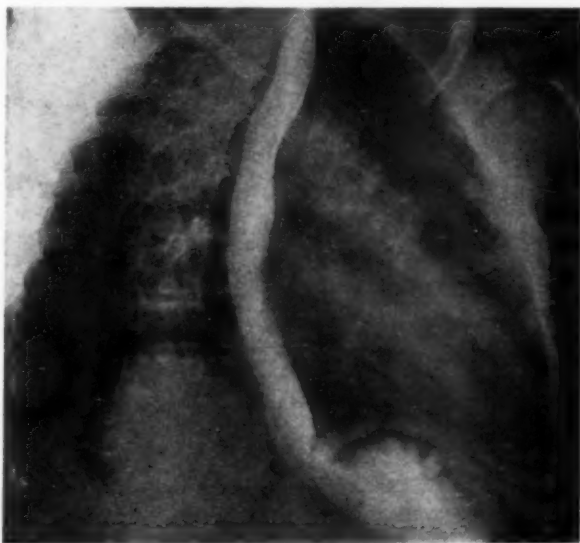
Roentgenogram made in the case of a woman, 31 years of age, who for several years had indefinite symptoms referable to the epigastrium. She had been examined in gastroenterological clinics and radiographic studies were reported normal. The symptoms, which were described mainly as "indigestion" and often manifested themselves when the patient was prone, suggested hiatal hernia. No herniation could be demonstrated by roentgen examination with the patient in the right oblique prone posture, but it was noted that the hiatal orifice always remained open as shown on the roentgenogram. The case, therefore, was considered to be one of cardioesophageal relaxation, possibly an early stage of hiatal hernia. At esophagoscopy, the only abnormality noted was failure of the hiatus to close. With the tip of the esophagoscope near the site of the hiatus esophagus, one could look directly into the stomach during inspiration, indicating that there was incompetency of the diaphragmatic sphincter.
